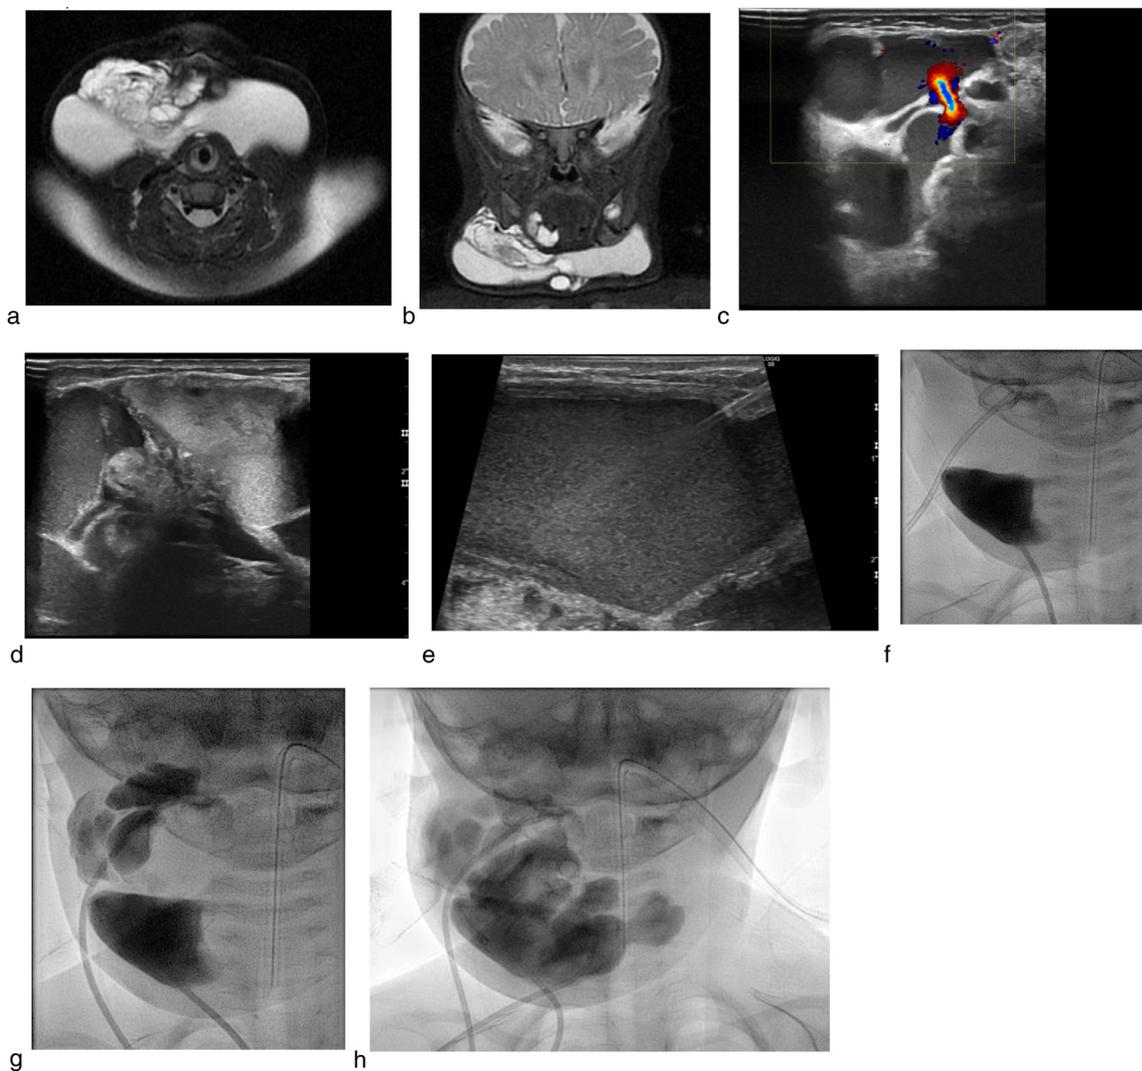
8-month-old female with large macrocystic LM of the anterior neck. Drains were placed and serial sclerotherapy with doxycycline was performed over 3 days. Axial T2 fat-sat (a) and coronal STIR (b) magnetic resonance images show multicystic lesion in the neck compatible with macrocystic LM. Color flow (c) and grayscale (d) ultrasound images show multiple macrocysts, some of which contain echogenic fluid that likely reflects prior hemorrhage. Grayscale ultrasound image shows 6.5 French pigtail drainage catheter placement into a large macrocyst (e). Fluoroscopic images (f and e) after intralesional contrast injection through the percutaneous drains show appropriate position of the drains within the cysts without evidence of extravasation. Spot fluoroscopic image after sclerotherapy demonstrates appropriate opacification of the macrocystic LM without evidence of extravasation. (Note that a third drain had been placed in order to facilitate treatment of the entire lesion.)
